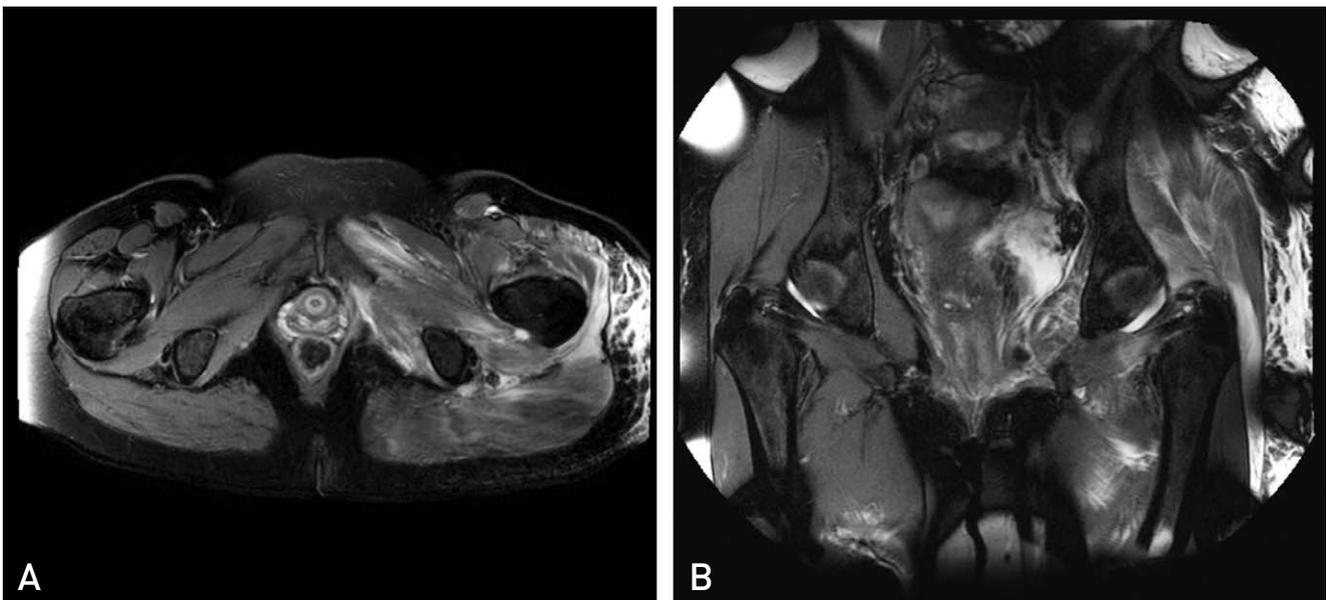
Preoperative magnetic resonance image of hip; High signal intensity at obturator externus/internus, quadratus femoris, gluteus maximus/medius/minimus, adductor brevis/minimus, pectineus muscles with overlying subcutaneous edema, left.
